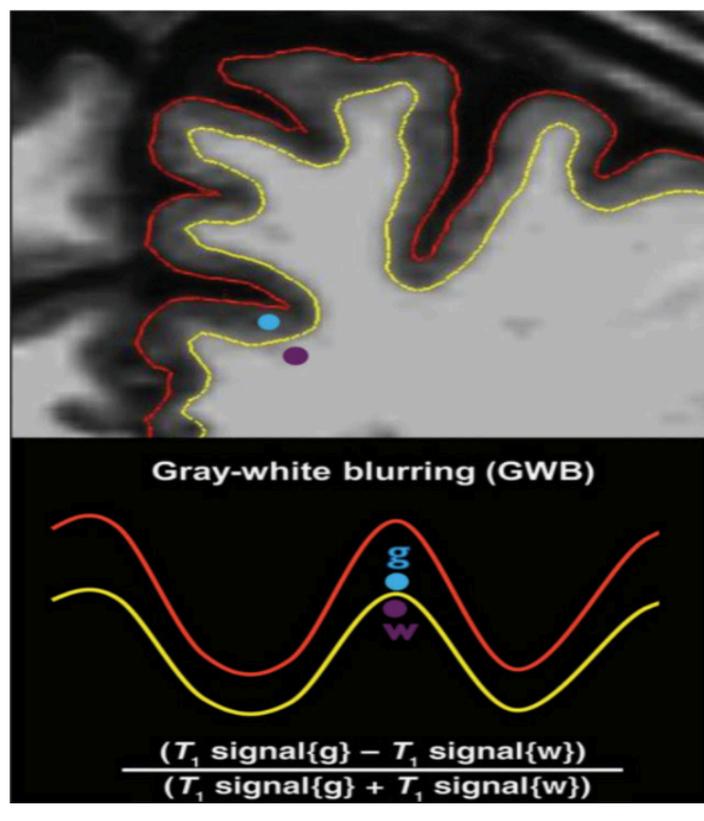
Computing GWB: Sampling points on T1-weighted MPRAGE image with gray-white (GW) junction surface (yellow line) and pial surface (red line). The blue dot represents the sampling location of the gray matter intensity value at 0.5mm into the gray matter relative to the GW junction. The purple dot shows the sampling location of the white matter intensity value at 0.5mm into the white matter relative to the GW junction (adapted from Blackmon et al., 2014).
